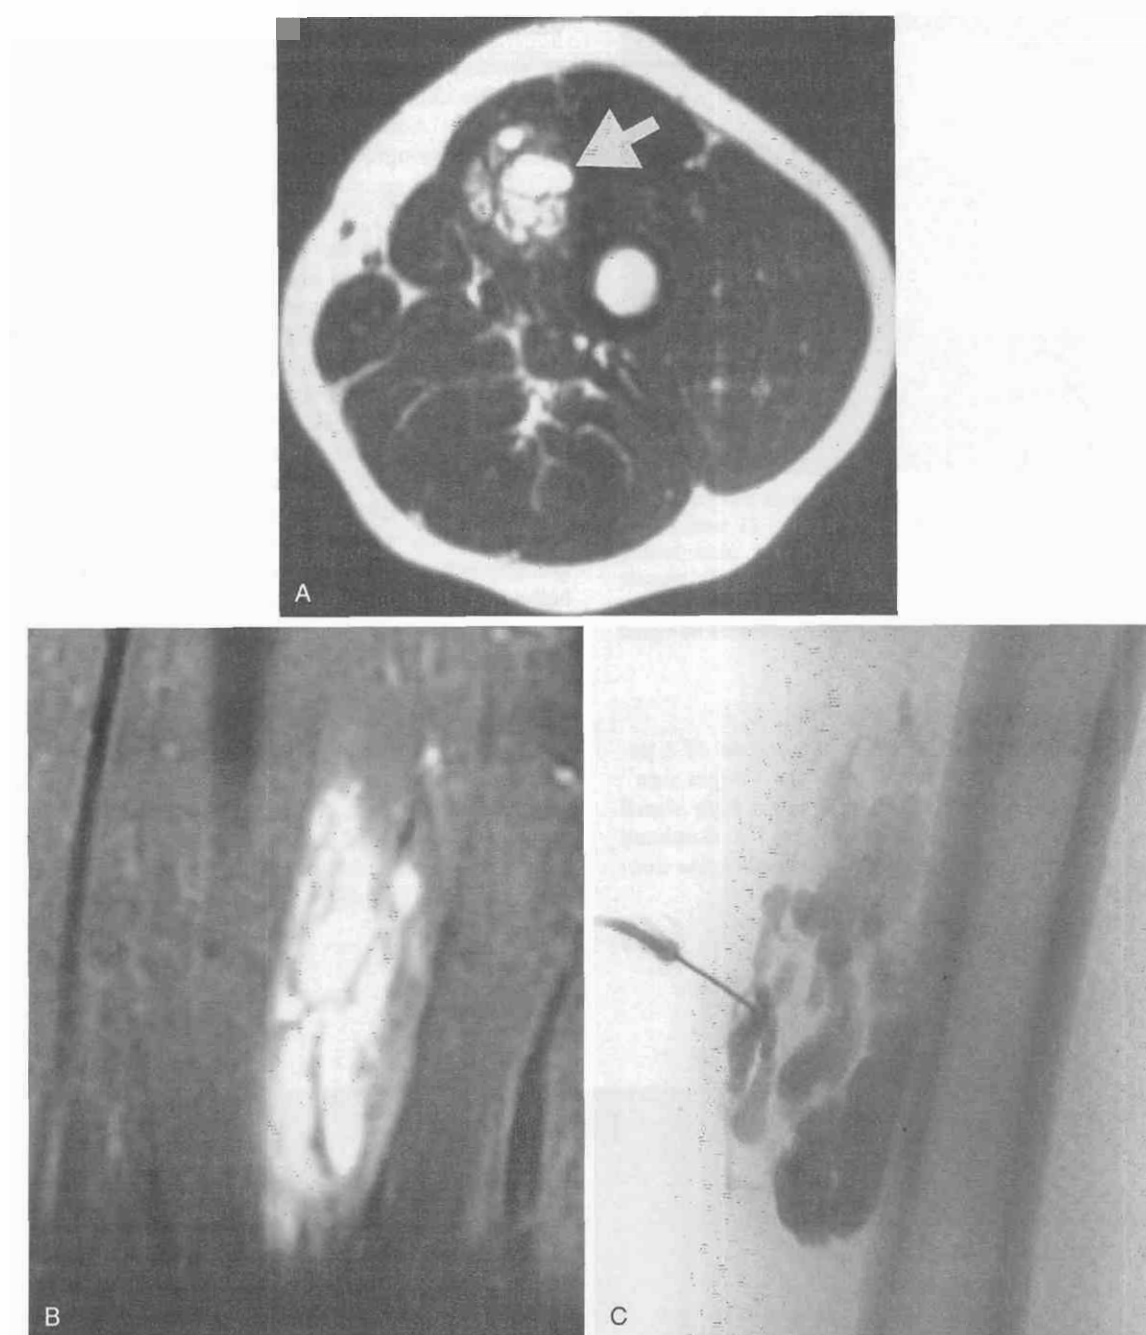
Venous malformation of the leg in an 11-year-old boy. *A*, Axial T2-weighted image (TR = 4000 msec, TE = 85 msec) shows a high-signal-intensity multilobulated mass (arrow) deep within the musculature. *B*, Sagittal postgadolinium T1-weighted image (TR = 500 msec, TE = 16 msec) with fat saturation shows diffuse enhancement of the lesion. Note the vertically oriented venous channels within the lesion. *C*, Correlative fluoroscopic spot image of the lesion obtained after direct contrast injection into the lesion in preparation for sclerotherapy.
